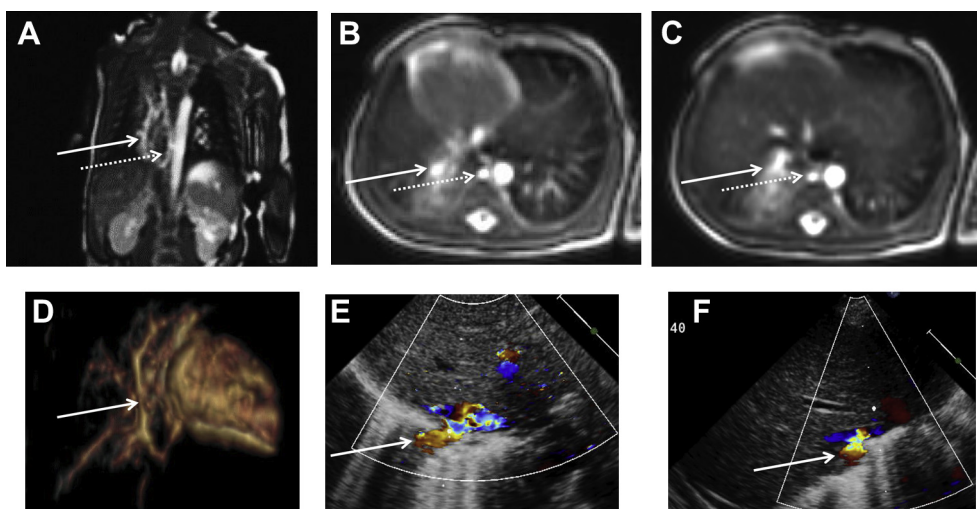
(A–C) Steady-state free precession magnetic resonance images. (A) Coronal view demonstrates the scimitar vein (white arrow) descending to the level of the diaphragm, and the azygous vein (dotted arrow). (B,C) Axial images reveal the scimitar vein crossing the diaphragm and inserting into the infradiaphragmatic, intrahepatic portion of the inferior vena cava (IVC); the azygous vein is also seen. (D) Three-dimensional reconstruction of gadolinium-enhanced magnetic resonance angiography (MRA) from a right posterior view displays the Scimitar vein. (E,F) Modified axial color Doppler echocardiographic views demonstrate similar findings to MRI views in B and C.
